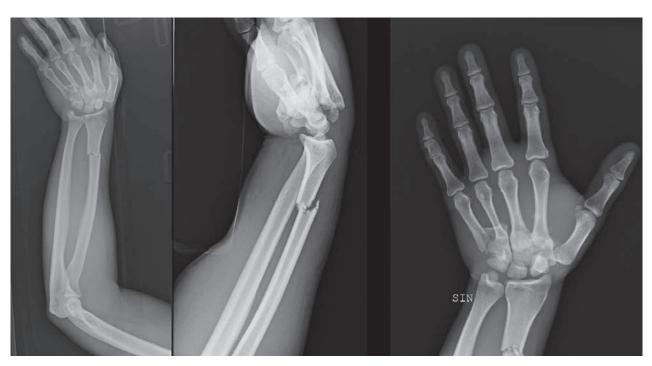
Initial X-rays showing dorsal dislocation of the fourth ulnar carpometacarpal joint, associated with a fracture of the trapezium, a burst fracture of the trapezoid bone and an extra-articular fracture of the third distal of the radius. Initial X-rays showing dorsal dislocation of the fourth ulnar carpometacarpal joint, associated with a fracture of the trapezium, a burst fracture of the trapezoid bone and an extra-articular fracture of the trapezium, a burst fracture of the trapezium of the trapezium.
